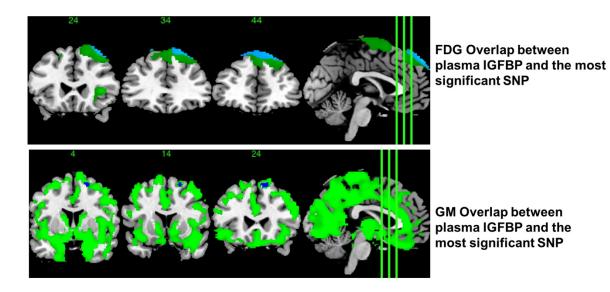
Brain areas showing overlap between either the GM or FDG and IGFBP2 result
